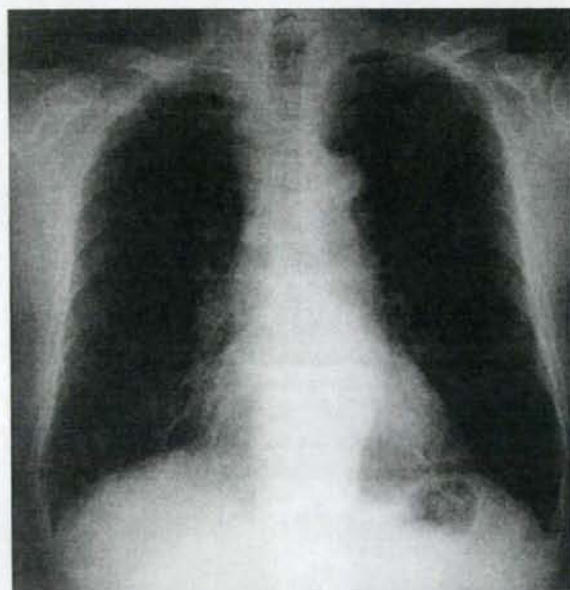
Chest X-ray from July 2001. Bilateral reticulo-nodular shadows are observed predominantly in the lower lung fields.
